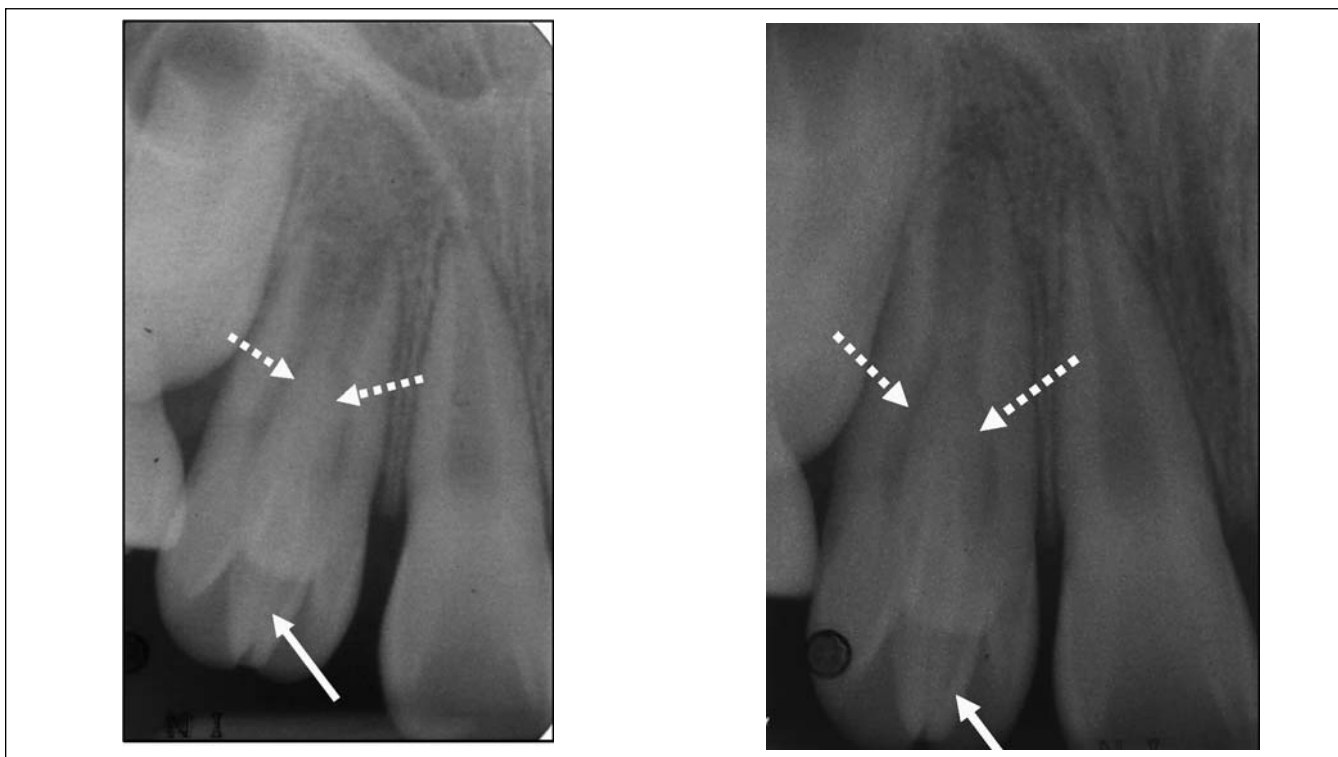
The periapical radiographs showing a DE (arrow) and a DI (dashed arrow) on the right maxillary lateral incisor. a) at the time of diagnosis b) at the time of review a year later
